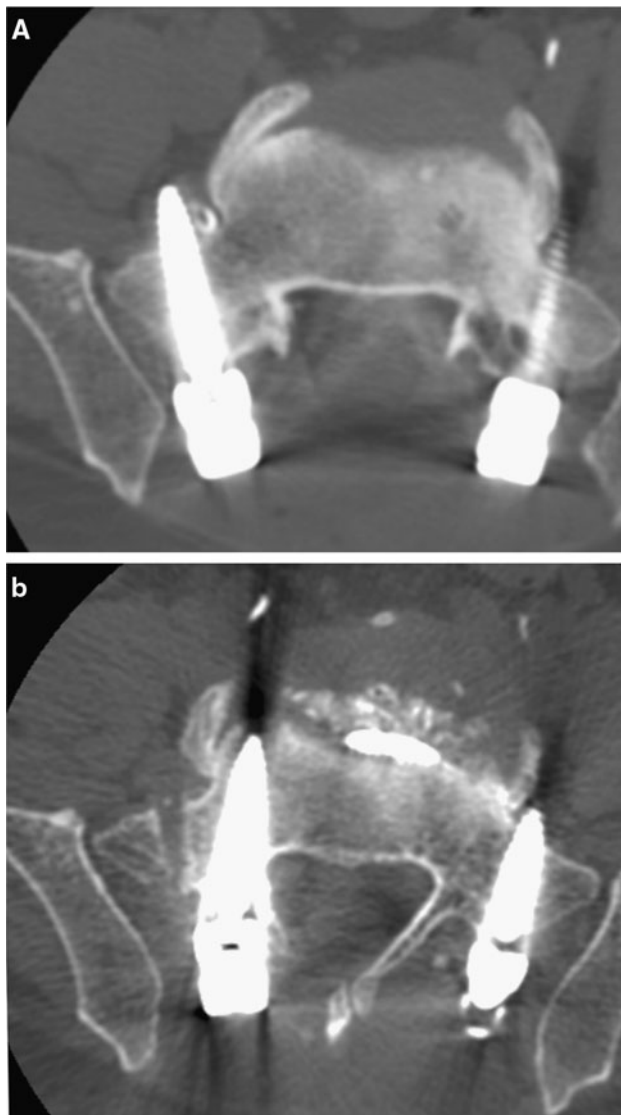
a CT after the right L5 rootgraphy shows that bilateral screws were not inserted through the pedicle and abutted the outer cortex of the vertebral body. The right S1 screw was inserted 17° outwardly and penetrated 8.6 mm distant from the anterior cortex of the sacrum. The right L5 nerve root is crushed between the pedicle screw and the lateral side of the S1 endplate, without any space to move. b CT after reinsertion indicates that the right screw was reinserted with 4° medial inclination and anchored in the vertebral body
